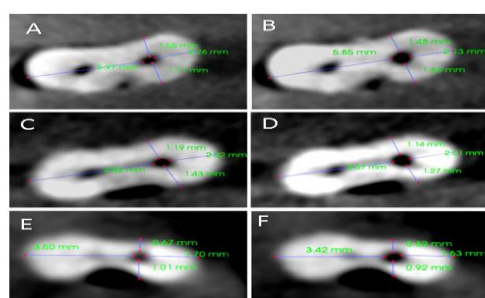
CBCT measurements; pre-instrumentation A: coronal, C: middle, E: apical and post-instrumentation B: coronal, D: middle, F: apical.
